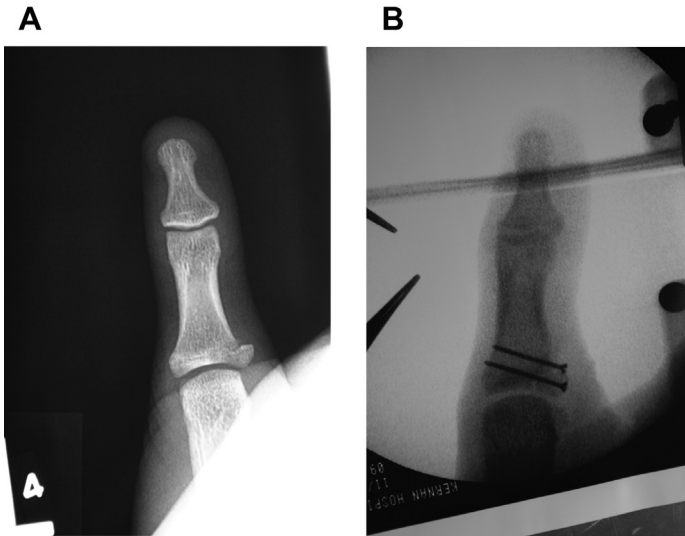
Thumb metacarpophalangeal ligament avulsion. Thumb metacarpophalangeal ligament avulsion injuries are more common than ligament ruptures in children. (A) The fracture is usually a Salter-Harris IV injury with intra-articular involvement seen best on posteroanterior radiographs. (B) Treatment of displaced fractures is anatomic reduction and fixation. In this case, the physis was nearly closed, so screws traversing the physis were chosen for better fixation. (Courtesy of Shriners Hospital for Children Philadelphia.)
